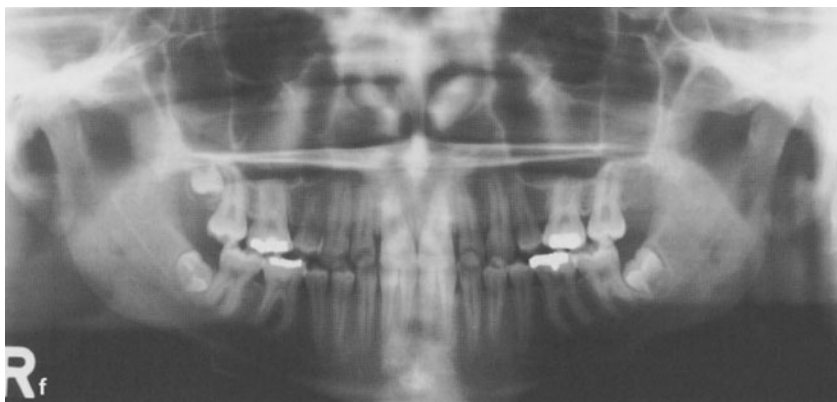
Real antemandibulism. f The panoramic radiograph does not disclose any asymmetry. g The measurements of the tracing of the panoramic view prove that both hemimandibles are equal in all sections. h, i The TMJ–ramus tomograms show that the condyles and their necks as well as the rami and angles are within normal limits in size and form. k The lateral cephalogram gives the true picture: the horizontal rami are too long compared with the other parts of the facial skeleton
